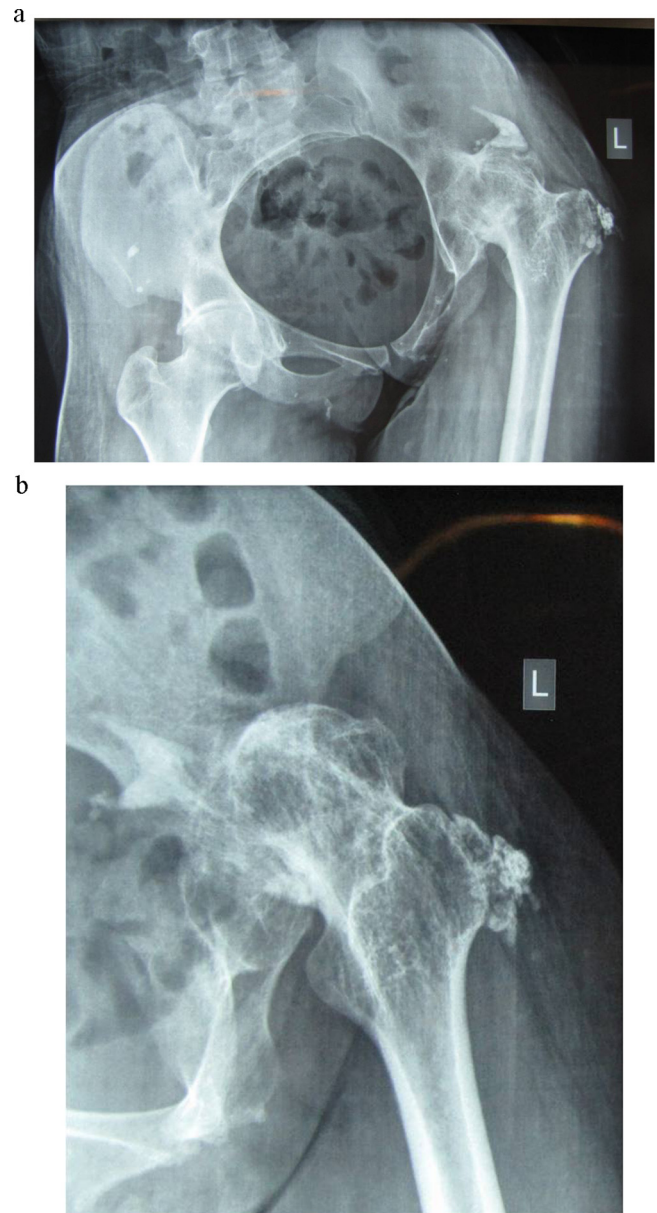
Pre-operative (a) anteroposterior (AP) pelvis and (b) lateral X-ray projections of the left hip.
